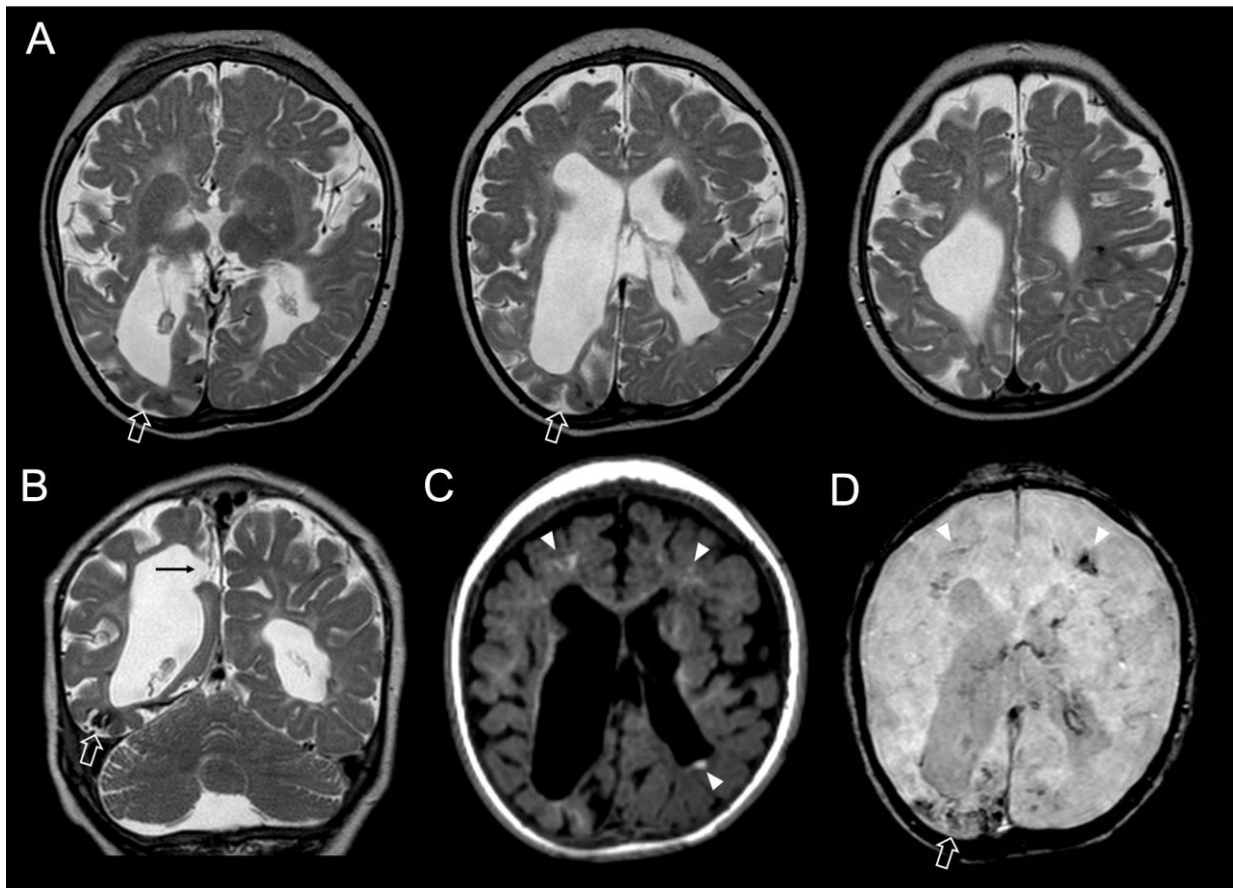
Neuroimaging of patient #3. Brain MRI Multiple bilateral AHS, porencephaly and deep brain calcifications.
